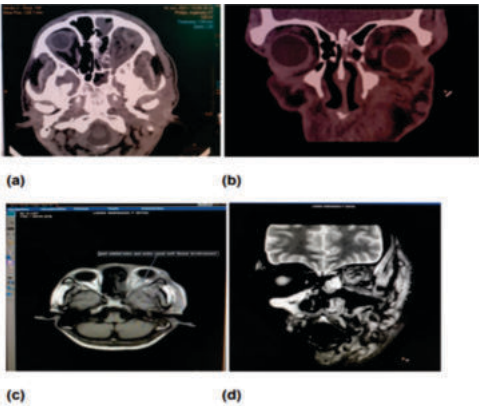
(a-d) : LT.rhino-oculo-cerebral mucormycosis. (a-b) axial and coronal CT-ORBITS showing soft tissue attenuated material with in the intra and extra-conal compartments of LT.orbit extending into PNS and inferior temporal fossa.(c-d) axial T1w and coronal T2w MR images showing T2 hyperintense granulomatous lesion involving PNS with fluid levels and showing rim enhancement on post contrast with orbital and inferior temporal fossa extension.
